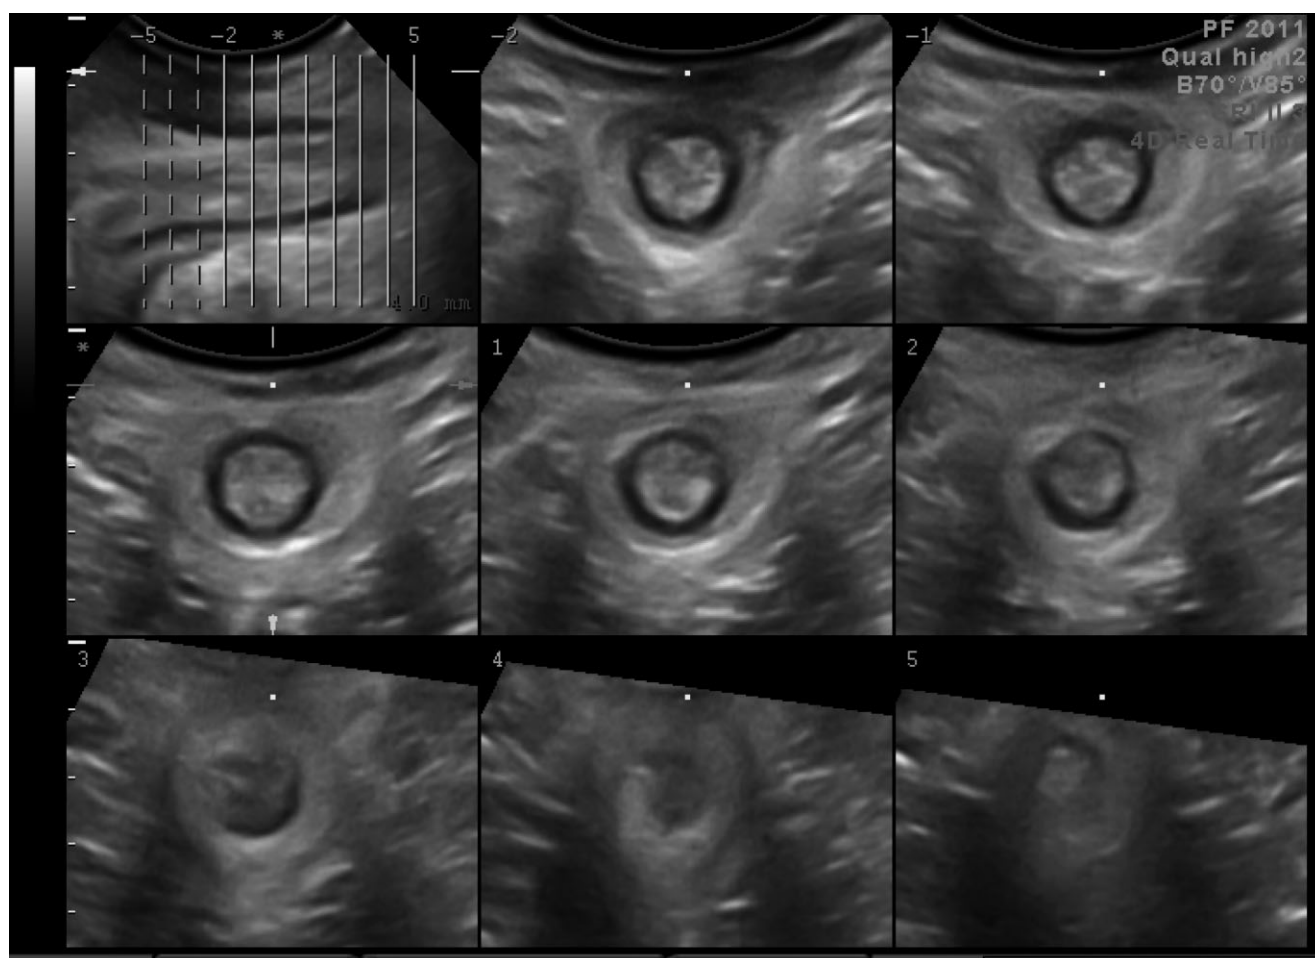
Translabial tomographic ultrasound imaging of the external anal sphincter. The top left image shows the mid-sagittal plane and the remaining eight slices are coronal images of the entire external anal sphincter, the locations of which are shown in the top left hand image
